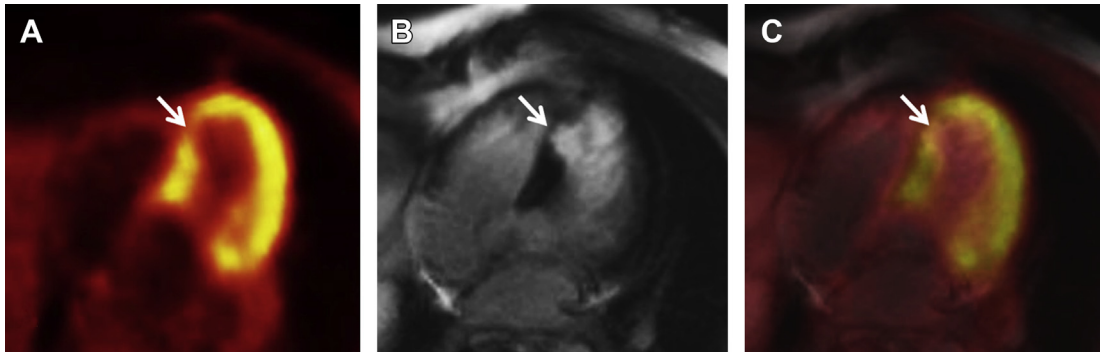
Cardiac PET-MR imaging in a 65-year-old man with a septal wall myocardial infarction. (A)  $^{18}\text{F}$ -FDG PET 4-chamber long-axis PET reconstruction shows focal region of decreased radiotracer uptake (arrow) that colocalizes to the area of scar shown by (B) increased contrast enhancement (arrow) on a T1-weighted segmented gradient recalled echo late gadolinium-enhanced (LGE) MR image. (C) Fused  $^{18}\text{F}$ -FDG PET and LGE MR images.
